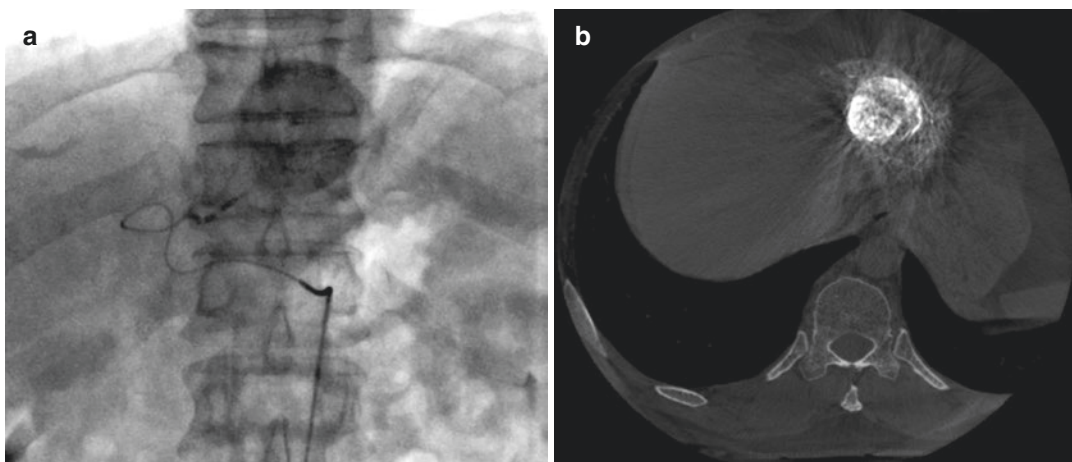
(a, b) Fluoroscopic and cone-beam 3DCT images showing lipiodol deposition during and post-procedure, respectively
